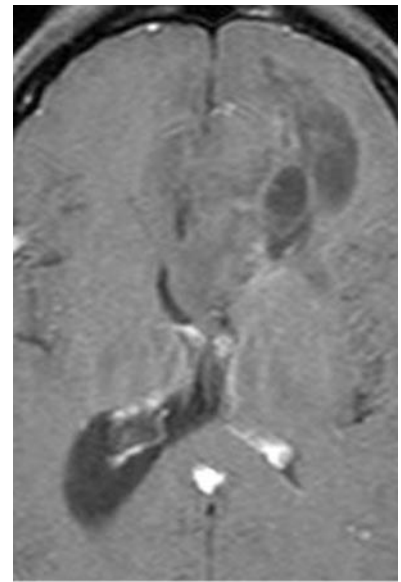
Oligodendroglioma. (a) Axial T2-weighted MR image shows a heterogeneous hyperintense mass (arrows) in the left frontal lobe with extension to the cortex and through the genu of the corpus callosum into the right frontal lobe. (b) Axial fluid-attenuated inversion-recovery MR image shows low signal intensity in more cystlike regions (arrowheads) of the mass. (c) Axial diffusion-weighted MR image shows low signal intensity of the mass, a finding that indicates absence of restricted water diffusion. (d) Axial contrast-enhanced T1-weighted MR image shows minimal enhancement of the mass.
